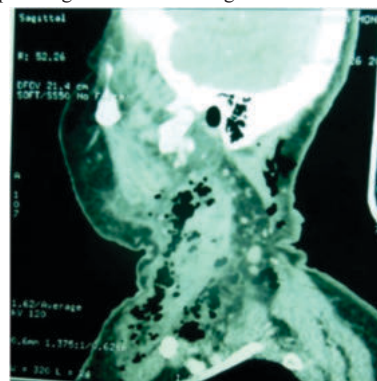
CT scan (Sagittal) showing gas in subcutaneous tissue plane
